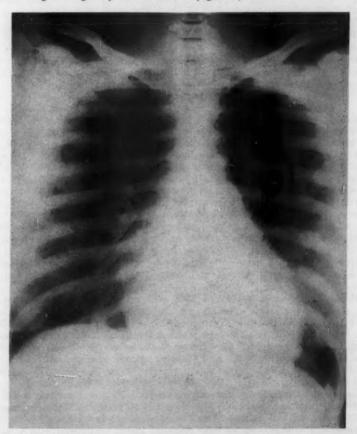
A-P portable chest roentgenogram, demonstrating cardiac enlargement and absence of pulmonary findings.
